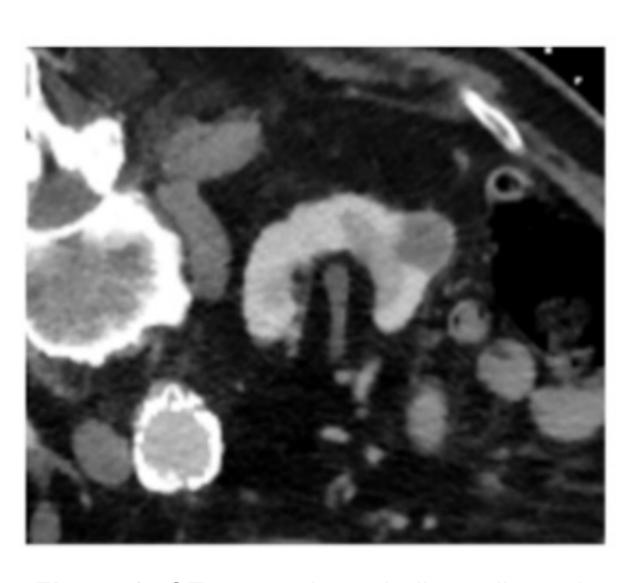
CT scan prior to balloon dissection. Tumor-to-bowel distance is 6mm.
